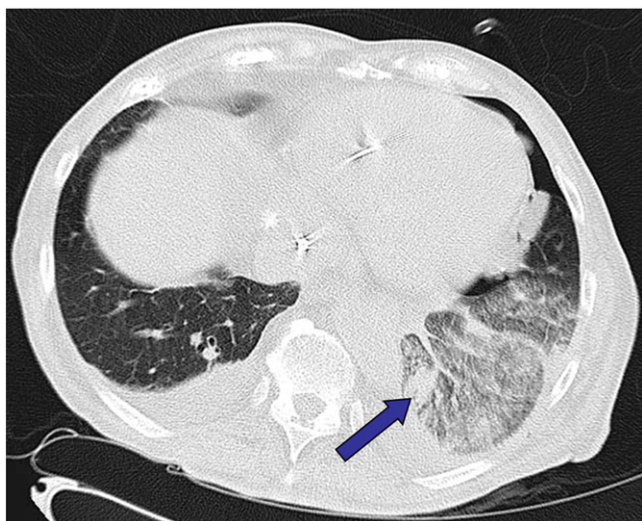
Chest CT scan reveals a nodular lesion (arrow) in the periphery of the left lower lobe in a background of ground glass opacification and septal thickening. Bilateral pleural effusions are present on imaging study despite the clinical presentation as left pleural effusion. The remaining left upper lobe and the right lung are unremarkable.
